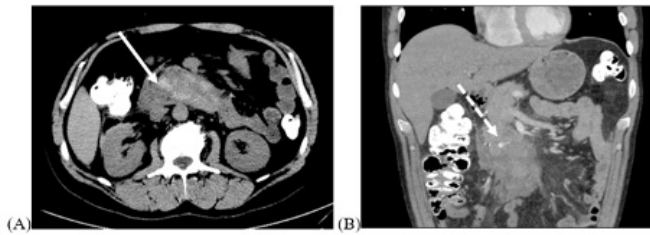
CT imaging pre-contrast (A) and with contrast in the arterial phase (B) showing evidence of a ruptured visceral artery pseudoaneurysm. (A) The axial section reveals a hyperdense area in the region of the inferior pancreaticoduodenal artery (solid arrow) in the absence of contrast, consistent with free blood. (B) The visceral artery pseudoaneurysm of the inferior pancreaticoduodenal artery (dashed arrow) is seen in the coronal section.
